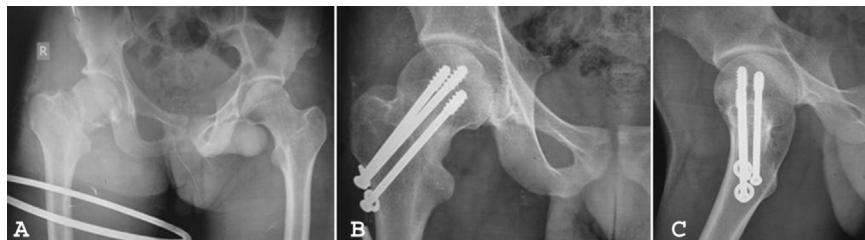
A: Anteroposterior radiograph of the pelvis with both hips of a patient showing right sided transcervical femoral neck fracture. B: Anteroposterior radiograph at 1 year after fixation with cannulated cancellous screws showing union. C: Lateral radiograph at 1 year after fixation with cannulated cancellous screws showing union.
